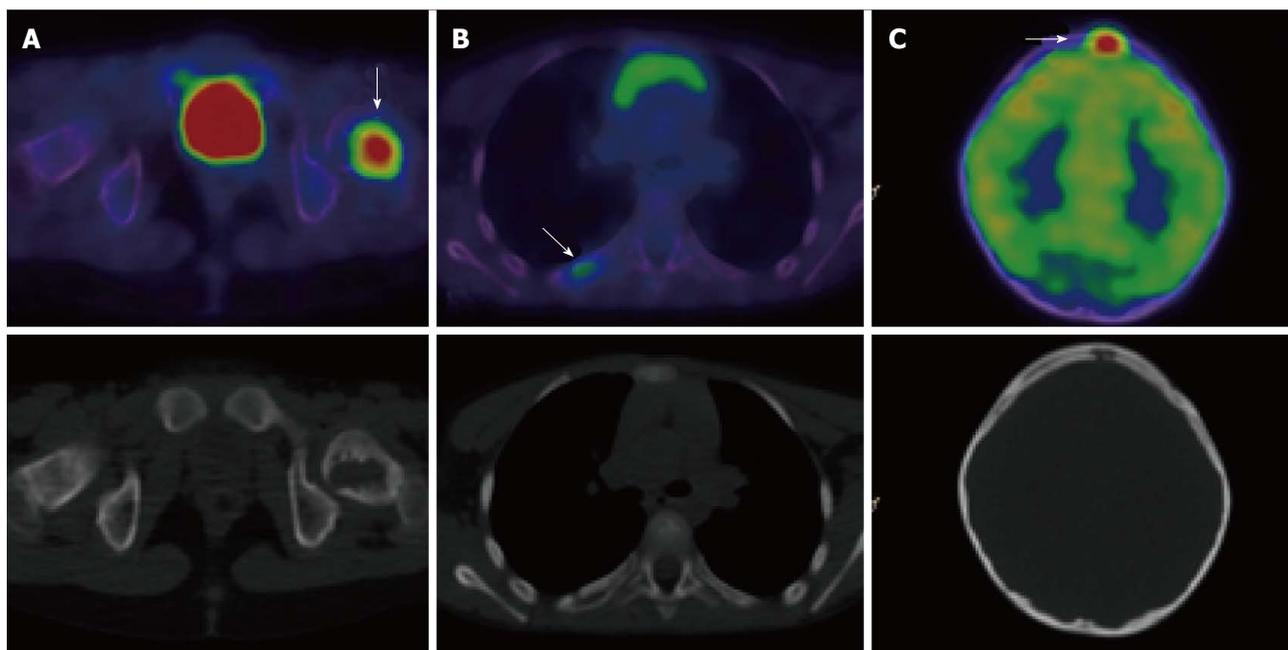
A 7-year-old male with Langerhans cell histiocytosis. Skeletal survey demonstrated an isolated left femoral lesion, confirmed on PET/CT (A, arrow). Additional lesions (arrows) in the right 6th rib posteriorly (B) and in the skull (C) were also identified on the PET/CT scan. Top panel: fused PET/CT images, bottom panel: low dose CT component of the scan. PET/CT: Positron emission tomography/computed tomography.
